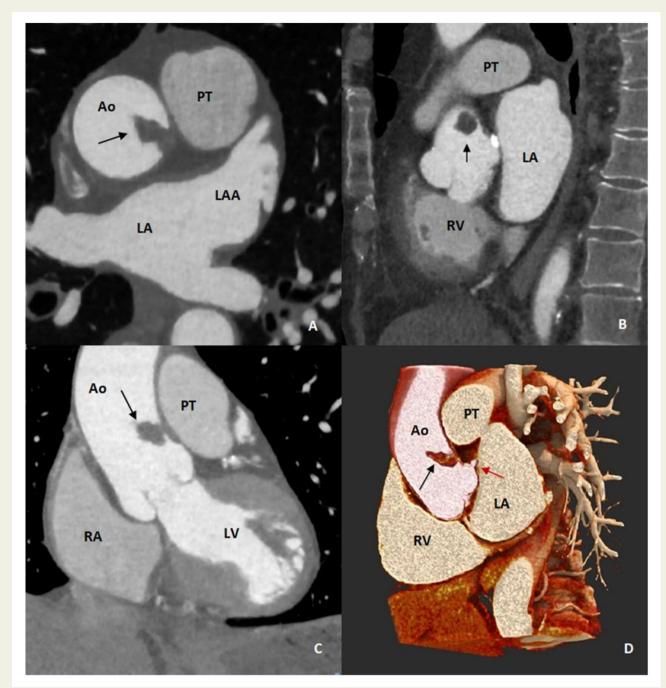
Computed tomography angiography of the supra-aortic arteries showing the floating thrombus in the ascending aorta (black arrow) close to the left main coronary artery ostium (red arrow) (A) axial plane; (B) sagittal plane; (C) coronal plane; (D) volume rendering reconstruction.
